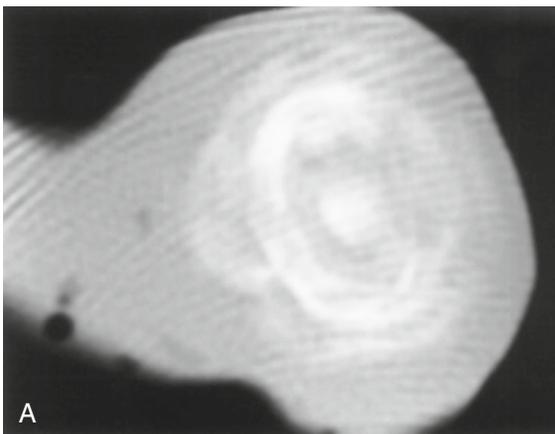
Histoplasmoma. (A) Chest CT image (soft tissue window) of a resected portion of lung demonstrates a sharply defined, rounded mass with dense central calcifications, surrounded by rings of lamellar calcifications. (B) Chest CT image (soft tissue window) through the left upper lobe of another patient reveals a sharply defined ovoid mass with dense “target” central calcification, surrounded by a single lamellar calcification.
